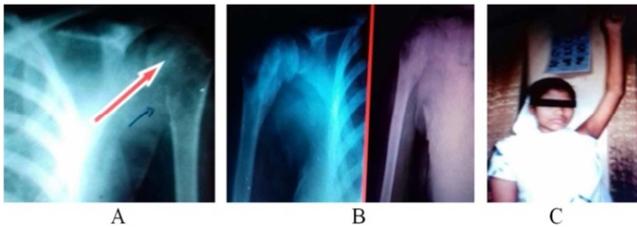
7A Pre-operative X-ray. 7B. post-operative X-ray at 6month & 18 months good incorporation of graft. 7C. Good abduction of left shoulder.
